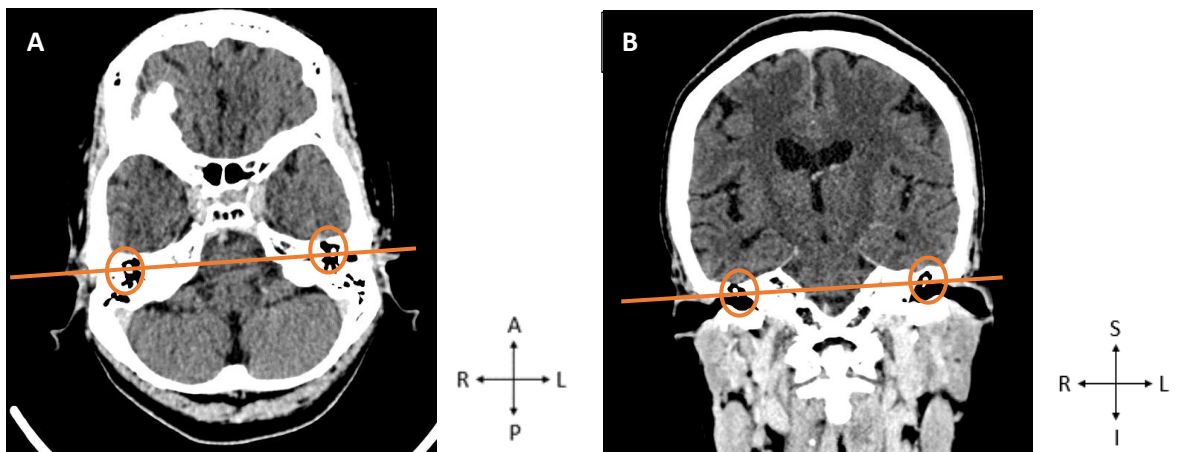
CT scans showing the brain in the axial view (A) and the coronal view (B), indicating the paired ear ossicles (encircled) with the reference lines (orange) traversing the ossicles. Image taken from the GSH PACS (20 October 2023). A - Anterior, R - Right, P - Posterior, L - Left, S - Superior, I - Inferior.
